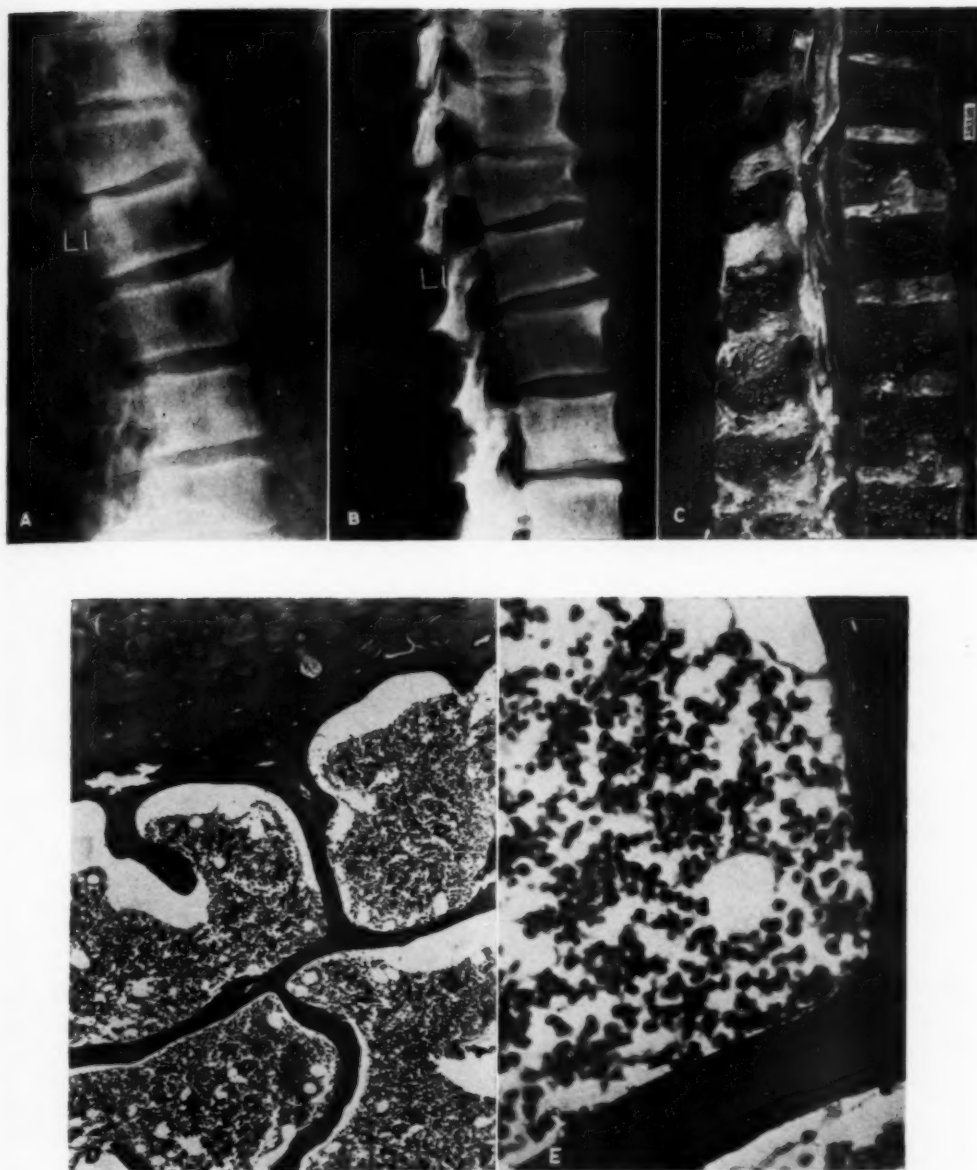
Roentgenologic and pathologic studies of the lumbar spine of a 67-year-old female who died of myeloma without exhibiting any significant osseous abnormalities.
